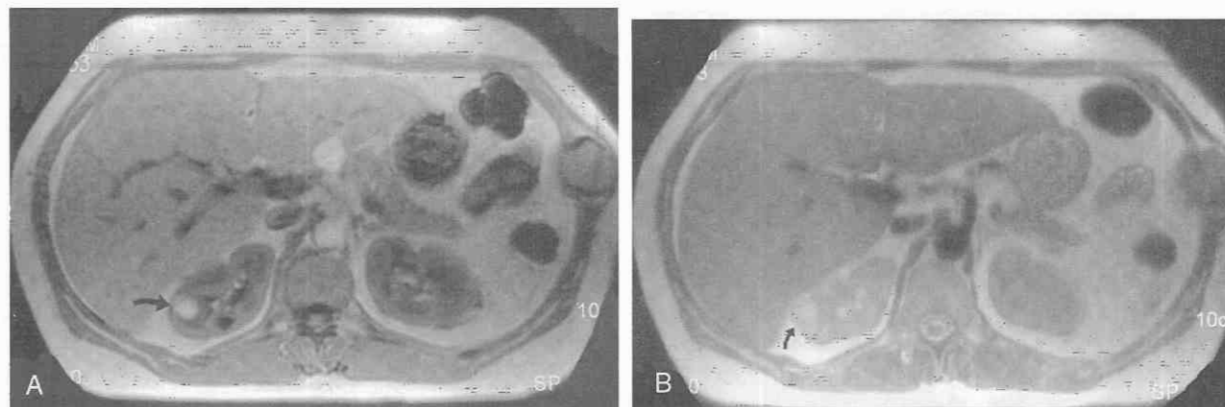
Hemorrhagic cyst. A, Axial T1-weighted gradient images demonstrate a small right renal upper pole cyst with increased signal (arrow). B, Corresponding T2-weighted image demonstrates increased signal (arrow) compared with the renal cortex. Previously diagnosed fibrous dysplasia of left ninth rib is incidental finding.
